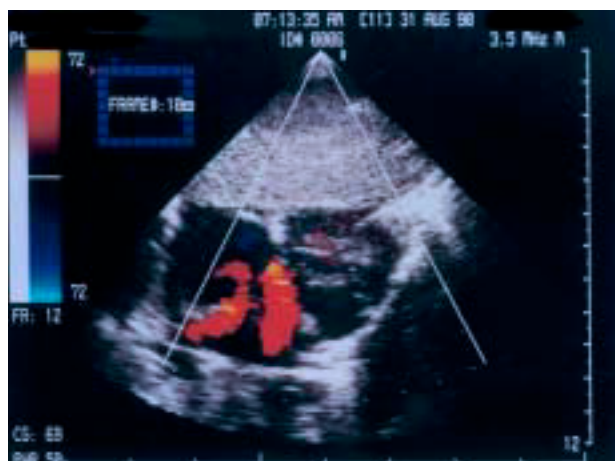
Subcostal four-chamber view with Doppler echocardiography demonstrates blood flow crossing two defects, a primum atrial septal defect and a ventricular septal defect of the inflow tract in a patient with an atrioventricular septal defect.
